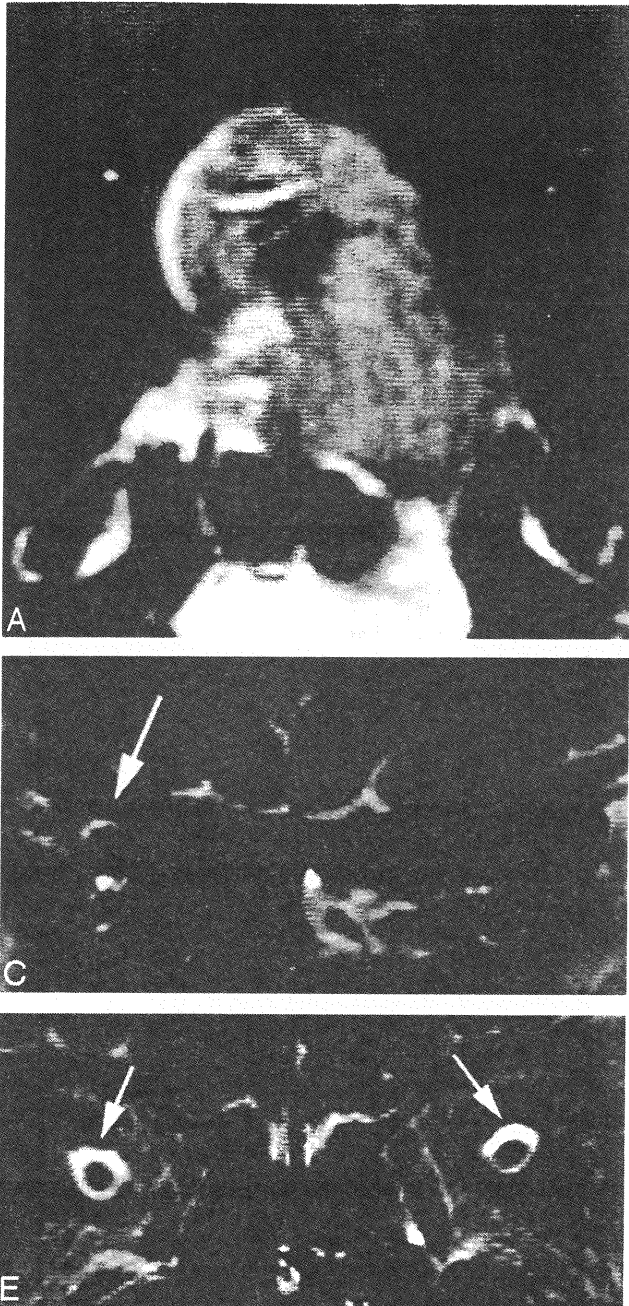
Case 3, a 42-year-old woman whose disease duration was 6 months. Right VA disturbance was recognized (right VA = 0.02; left VA = 1.5). A, Pituitary macroadenoma markedly compressed the optic chiasm especially the right side (white arrows). B-E, Hyperintensity was recognized in the right optic nerve on T2-weighted image (arrows). F-H, Hyperintensity in the right optic nerve lasted for 2 years after the tumor reduction (arrows).
